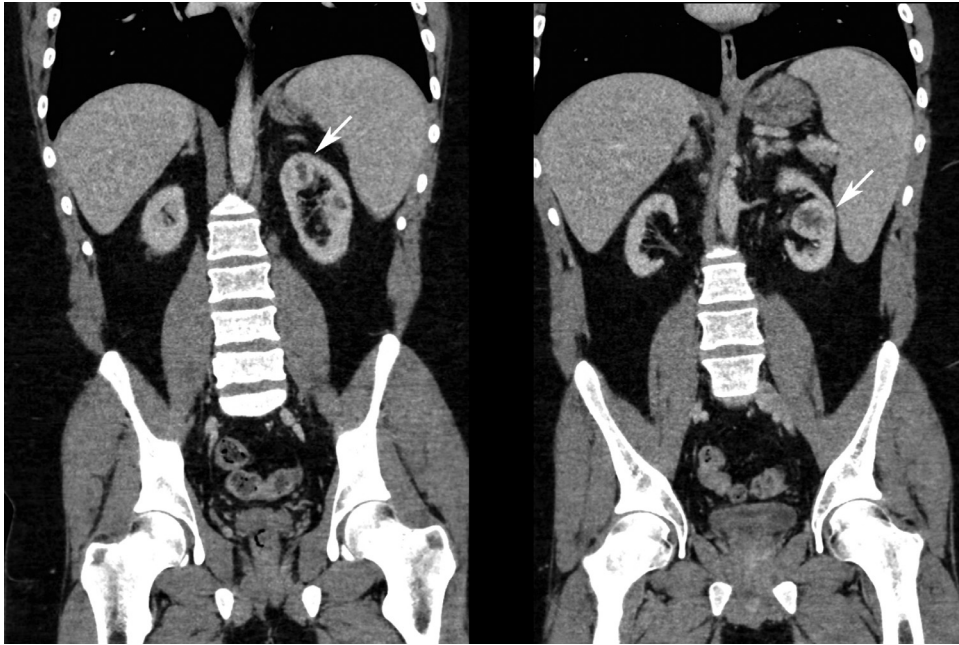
Arterial phase contrast-enhanced coronal CT images demonstrate enhancing lesions in the left kidney upper pole and midzone with central hypoattenuating areas.
